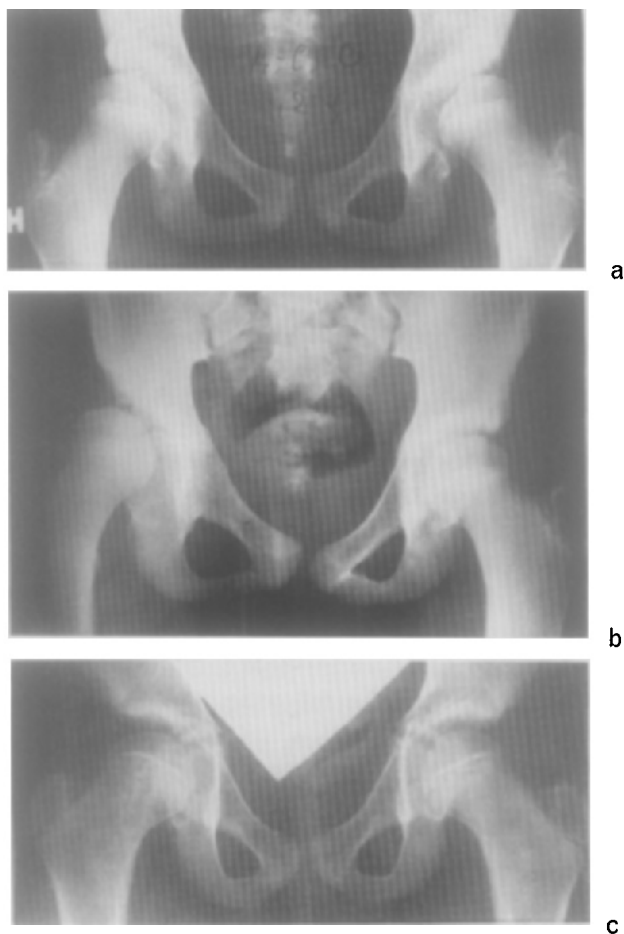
The three girls in the long-term follow-up, who did not show quite normal X-rays, all of them treated before we developed our present routine treatment. a. Slight subluxation left side. b. Marked subluxation right side. c. Slight shortening and thickening of the right femoral neck.
